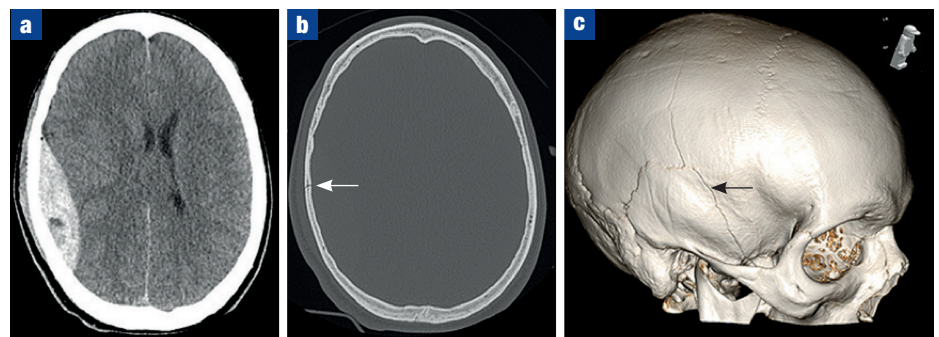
Extradural haemorrhage following a fall down a full flight of stairs. a. Unenhanced computed tomography scan of the head showing a large, lentiform extra-axial area of high attenuation consistent with a right extradural haematoma. b. A non-displaced fracture involving the right parietal and temporal bones and extending into the skull base (arrow). c. Three-dimensional volume-rendered image showing the extent of the fracture (arrow).
